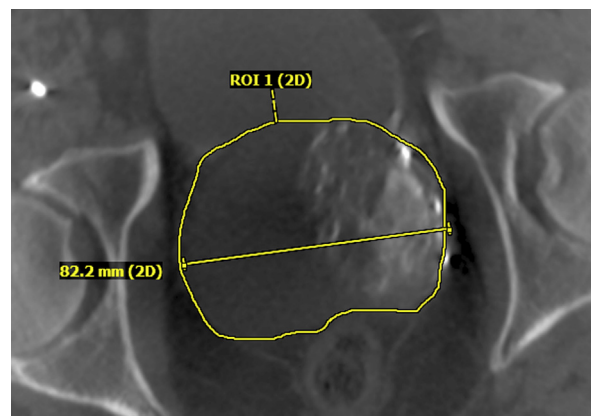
Axial cone-beam CT image of prostate gland used to confirm appropriate target vessel(s) for embolization and for measurement of PGV. Image was obtained during left prostatic artery contrast injection, with the entirety of the left hemi-prostate perfused.
